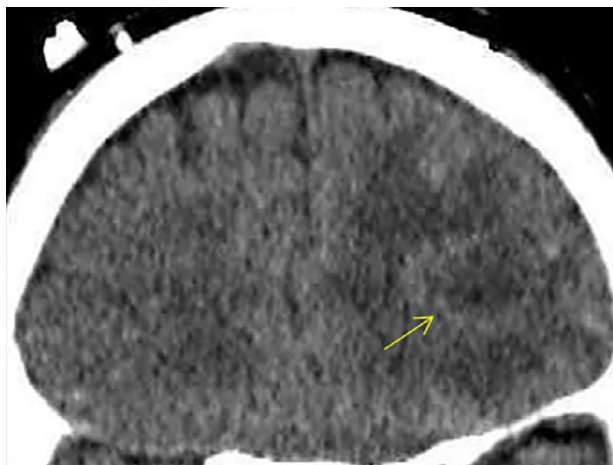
Coronal computed tomography without IV contrast shows left frontal lobe hypodense lesion.
